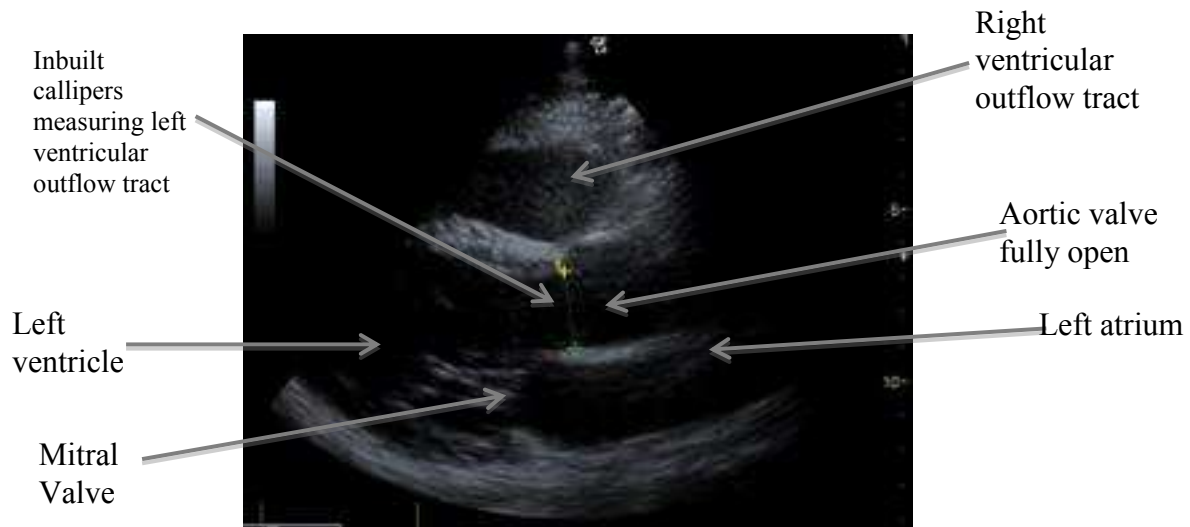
Parasternal view of the aortic valve and diameter measurement of left ventricular outflow tract when participant in systole.
